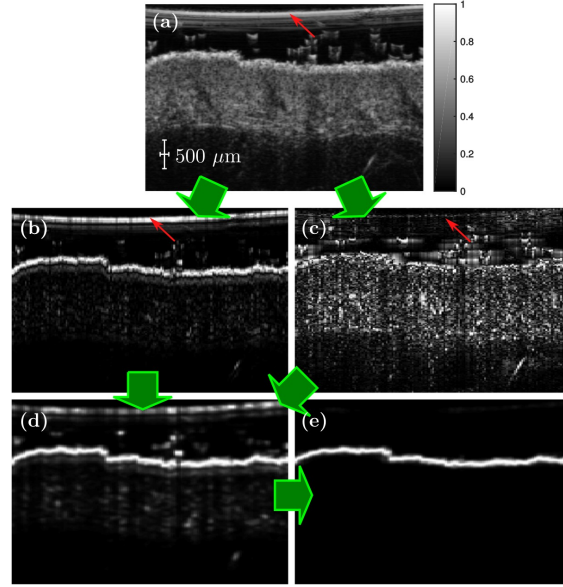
(a) Normalized ultrasound image $I(x, z)$ (gray). (b) M^{ver} map (c) M^{mem} map (d) M^{com} map. (e) M^{epi} map. Red arrows point at the membrane artifact, which is very strong in the map M^{ver} , absent in map M^{mem} and weak in the combined map M^{com} . Notice that the neighbor map efficiently cleans the map M^{com} to get the final indicator map M^{epi} .
